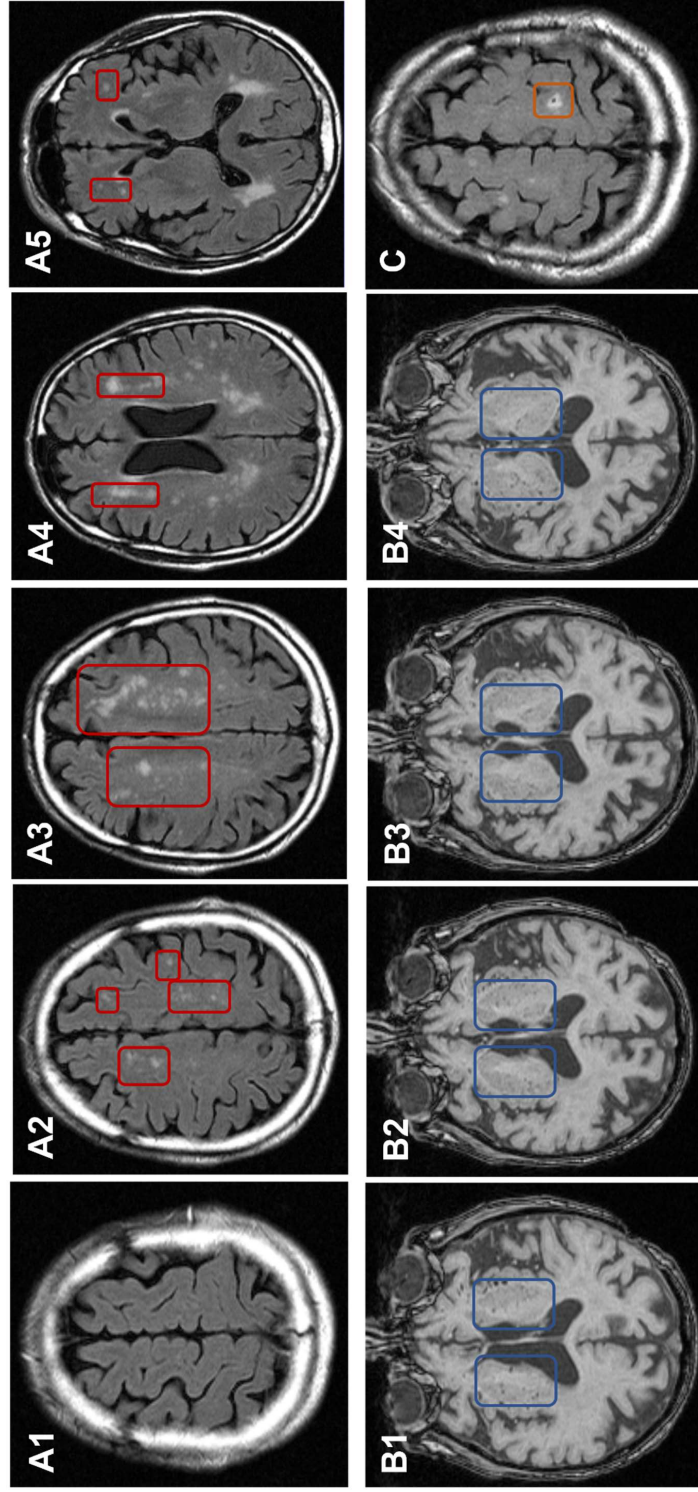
Visual assessments of white matter hyperintensities (A1-A5), perivascular spaces (B1-B4), and lacunes (C) on axial magnetic resonance imaging sequences
